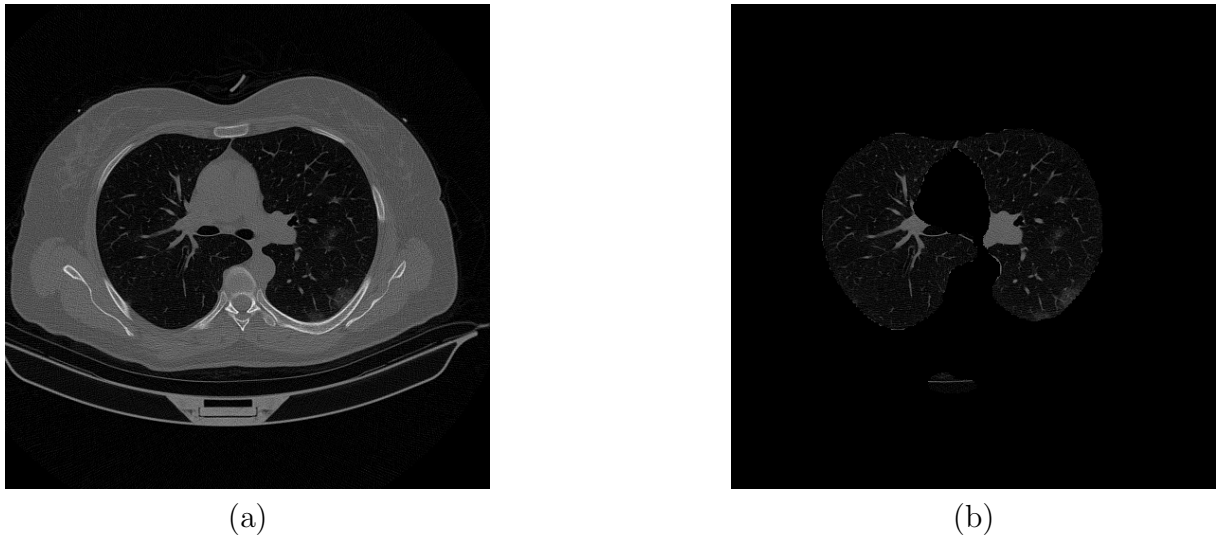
Example of image used in both frameworks. (a) Original CT image. (b) Segmented CT image where the lung parenchyma is preserved.
